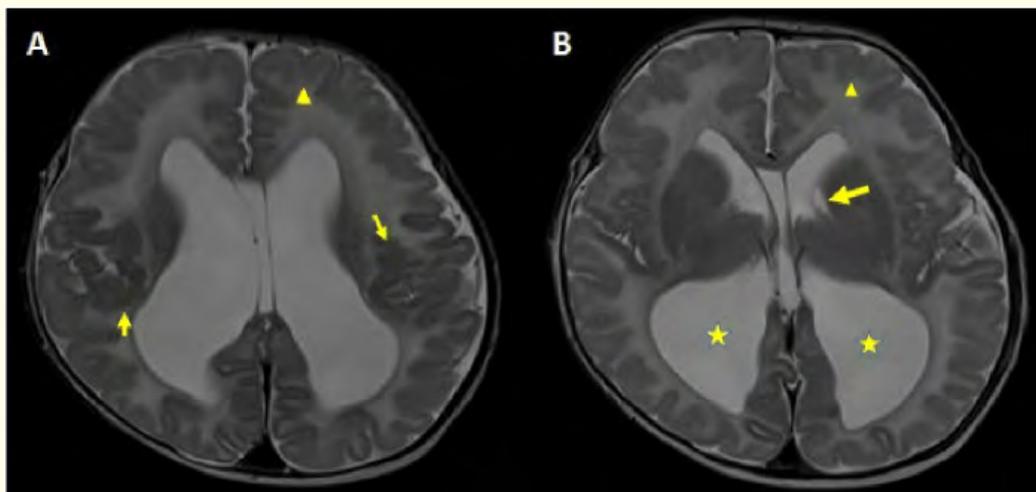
T2W Axial MRI images of the brain at the level of the body of lateral ventricles (A) at the level of the caudothalamic interface (B).
